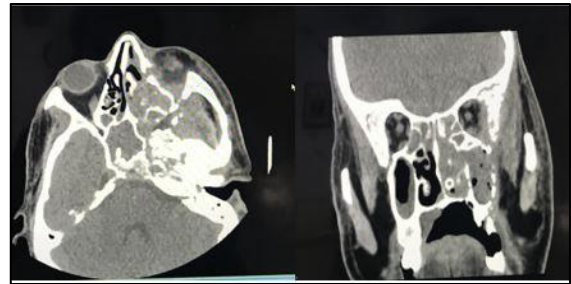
Contrast enhanced CT Scan of a patient showing features of osteomyelitis of left maxilla with air foci with bilateral ethmoid and sphenoid sinus involvement.
